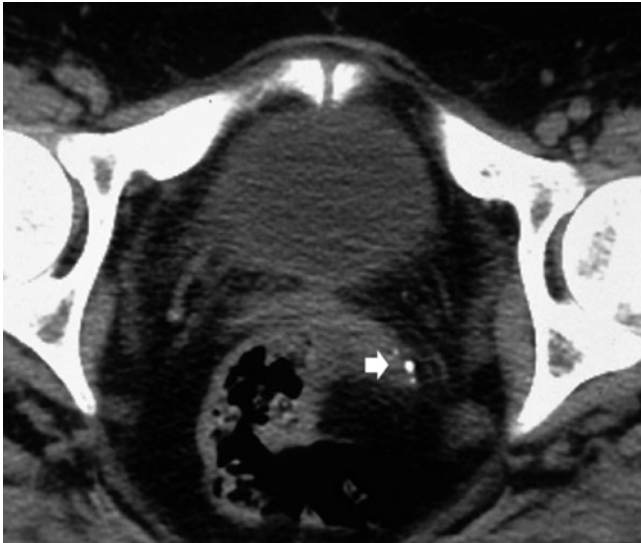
Indirect signs of renal calculi. Unenhanced CT. Transverse plane. Comet-tail (*arrow*) adjacent to pelvic phleboliths consisting of eccentric tapering of soft tissue extending from one surface of the calcification (Courtesy of Prof. E. Quaia)
